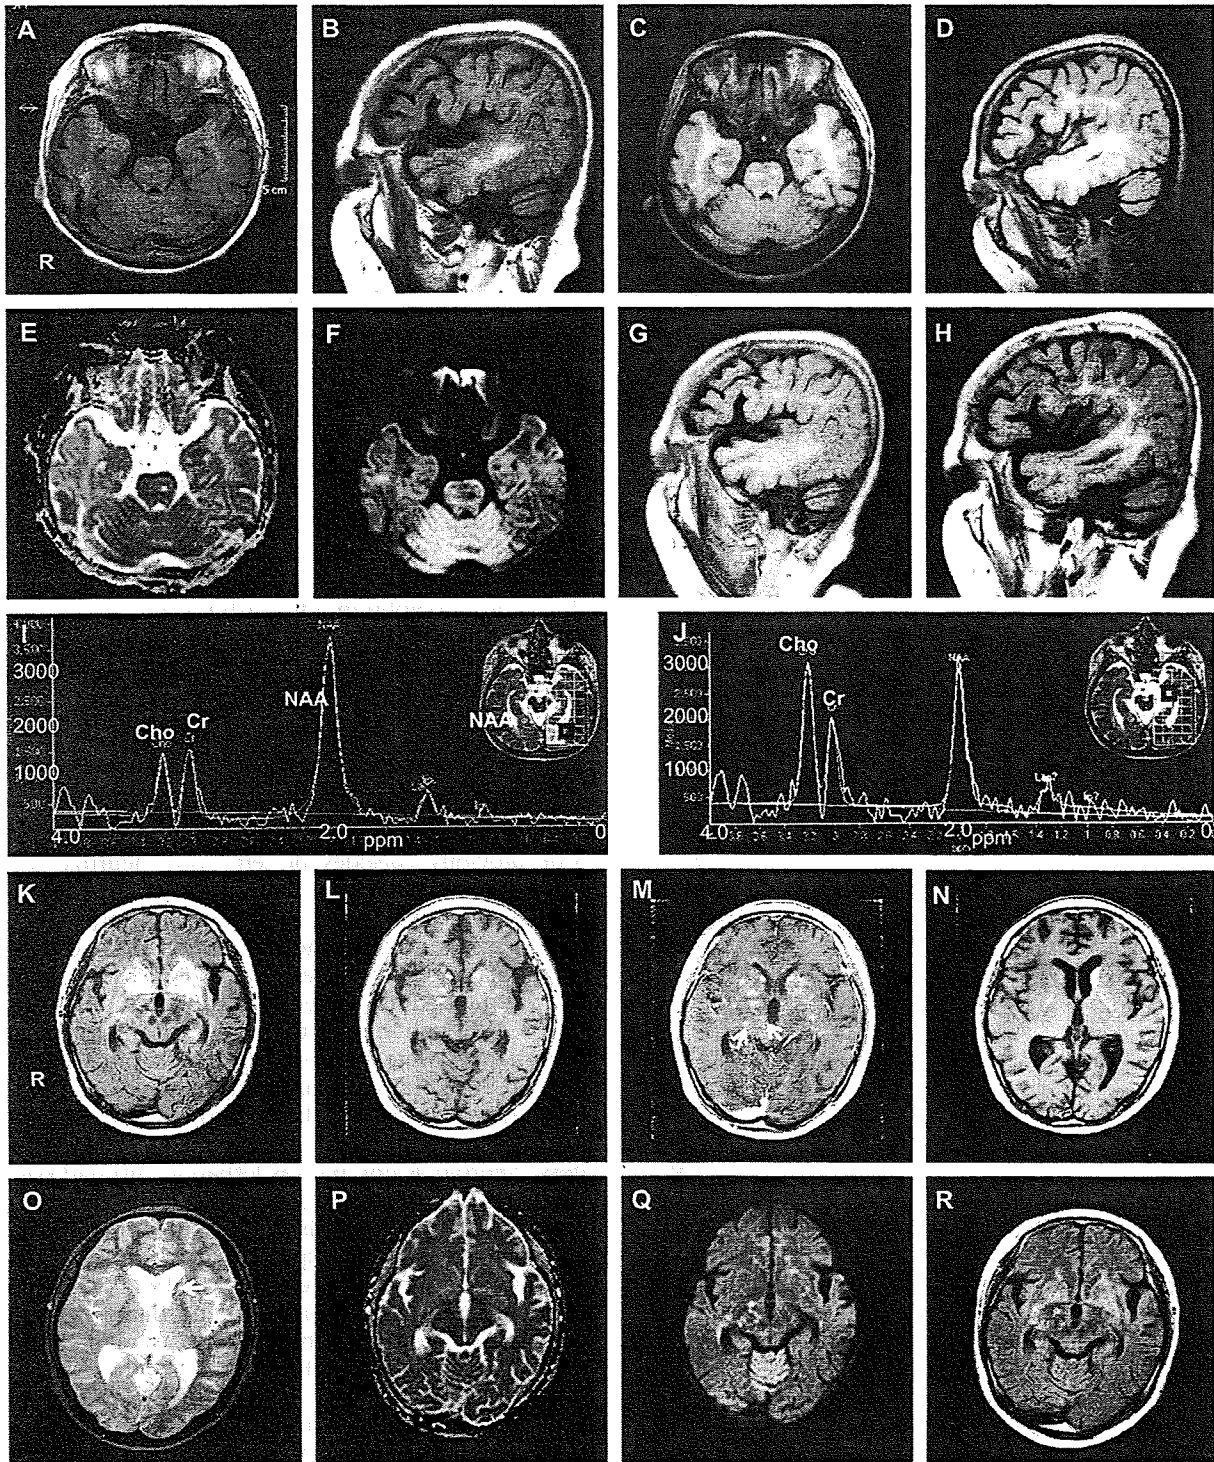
The extensive brain lesions in case 1 seen on MRI and MRS (A–J). (A,B) FLAIR image, showing mild hyperintensity in both temporal lobes, taken 5 months prior to relapse. (C,D) The temporal lobe lesions become extensive at relapse. (E) ADC map showing high diffusivity in both temporal lobes. (F) DWI showing hypointensity in the temporal lobes. (G) Although two courses of methylprednisolone pulse therapy (1 g/day for 3 days) followed by intravenous administration of hydrocortisone (50 mg/day) had no effects, the patient promptly improved following three courses of plasma exchange
